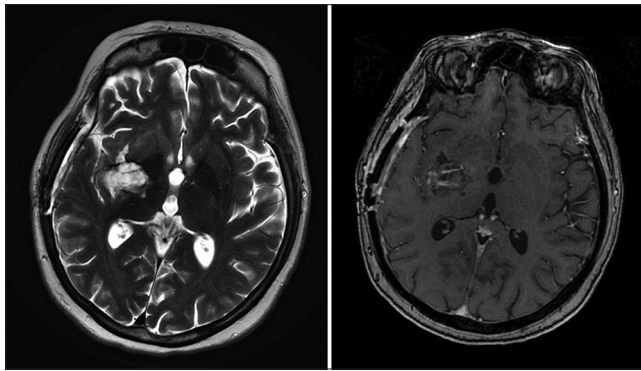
Brain magnetic resonance imaging after 6 weeks from surgery depicts a tumor bed cavity with complete resection. A slight gadolinium uptake was seen within the tumor cavity which represents remnant of fibrillary surgi-cells packing (ethicon) from the second surgery
